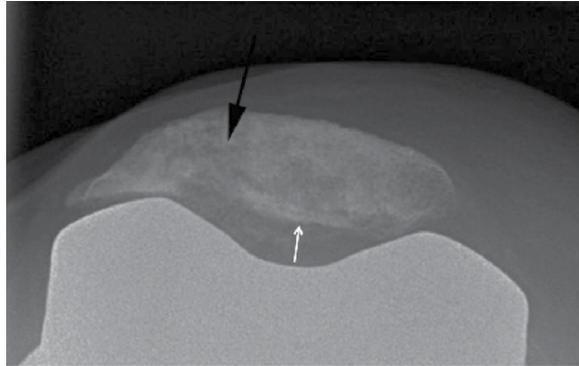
Patellar Osteolysis. A 75-year-old man, three years after total knee replacement. Axial radiograph (Merchant view) shows osteolysis of the lateral facet of the patella (black arrow) due to the loosening of both the total knee prosthesis and the patellar prosthetic button (white arrow). There was clinical suspicion of infection but cultures were negative.
